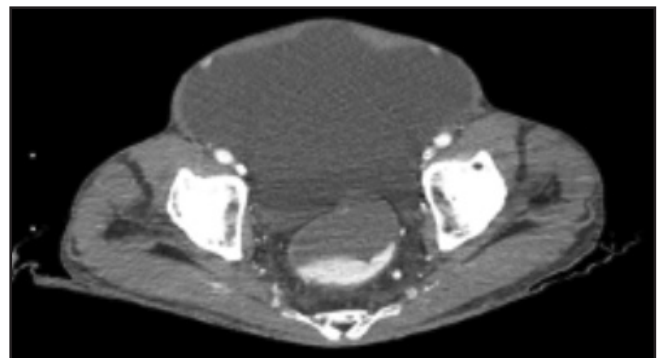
Venous phase CTA demonstrating active extravasation in the rectum.
